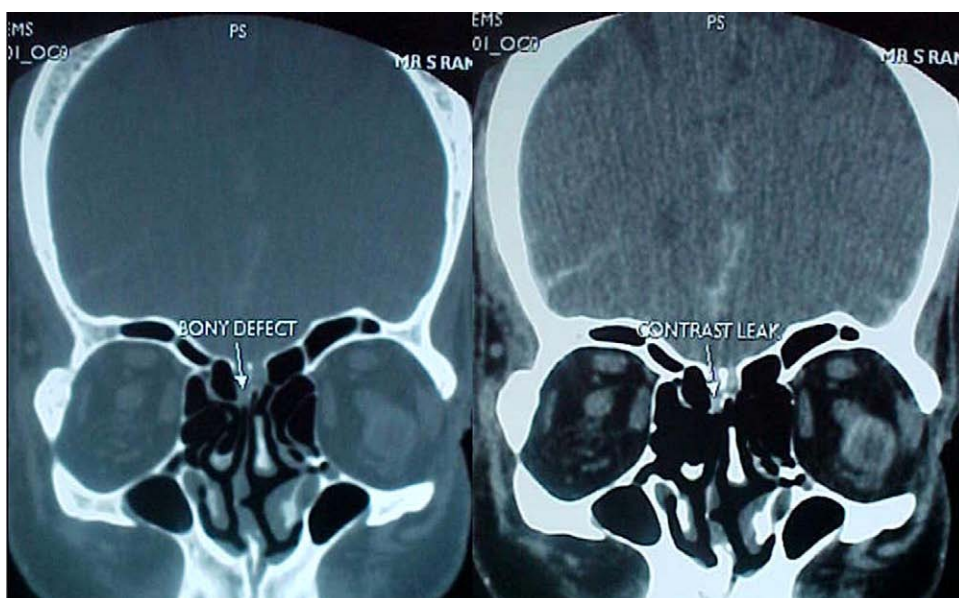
Computed tomographic cisternogram showing site of CSF leak.
